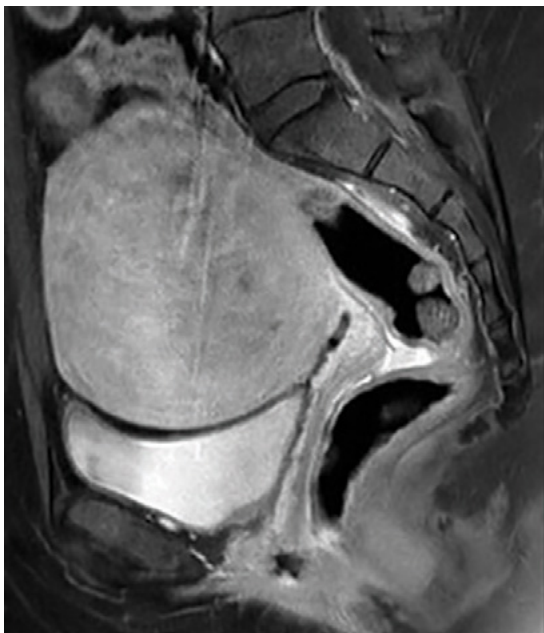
Sagittal MRI T1 post-contrast. a) Pre-embolisation, demonstrating large enhancing fibroid b) Post-embolisation, showing volume reduction and non-enhancement of the fibroid.
